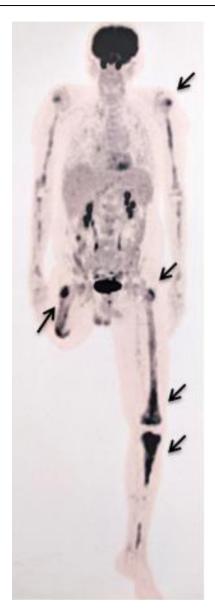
Figure $1-_{18}$ FFDG-PET Scan with bone inflammatory lesions (black arrows).
